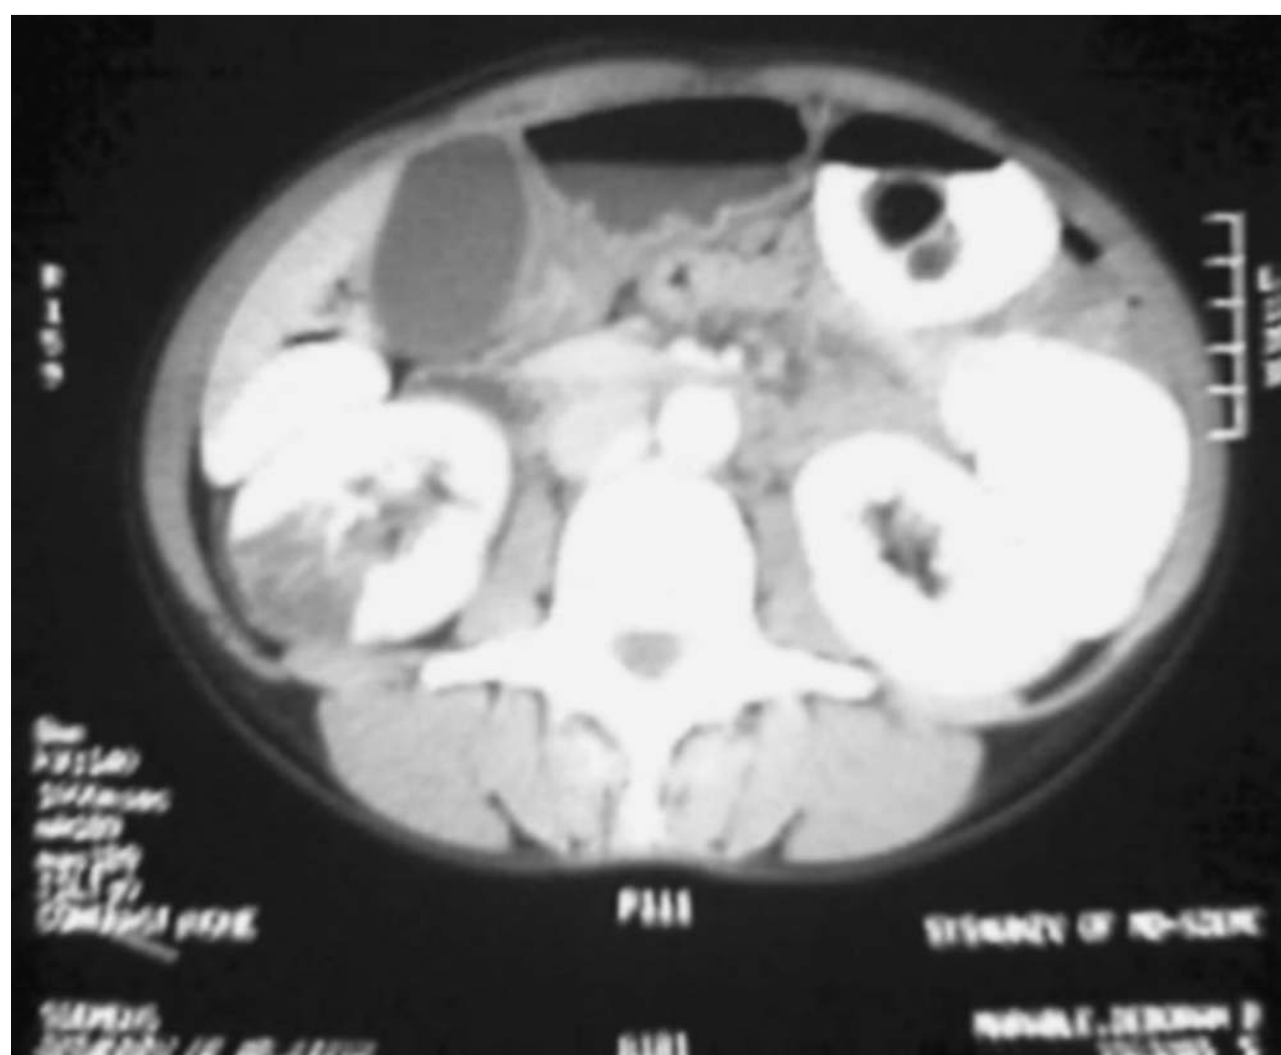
Abdominal CT scan with IV contrast: wedge-shaped right renal infarct in a patient with *Staphylococcus aureus* endocarditis of her mitral valve; splenic infarcts were also present.
